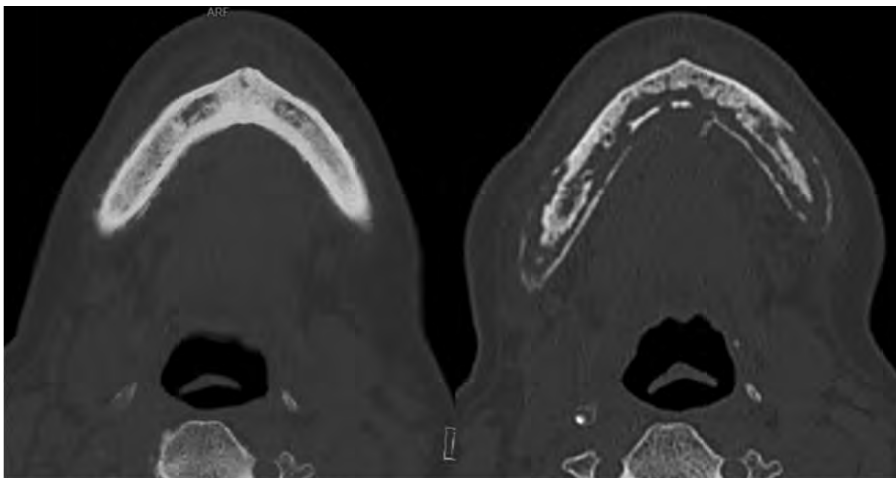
Bone CT of the mandible. On the left, June 2017 and on the right, December 2017.
